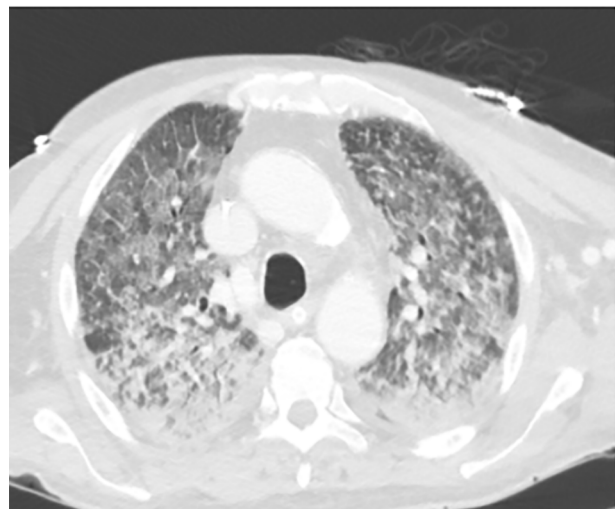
Axial chest computed tomography. Alternative text for visual assistance: Axial chest CT obtained above the carinal bifurcation and below the aortic arch. In the lung parenchymal window, a bilateral reticulonodular pattern can be observed, predominantly involving the posterior and central regions.
